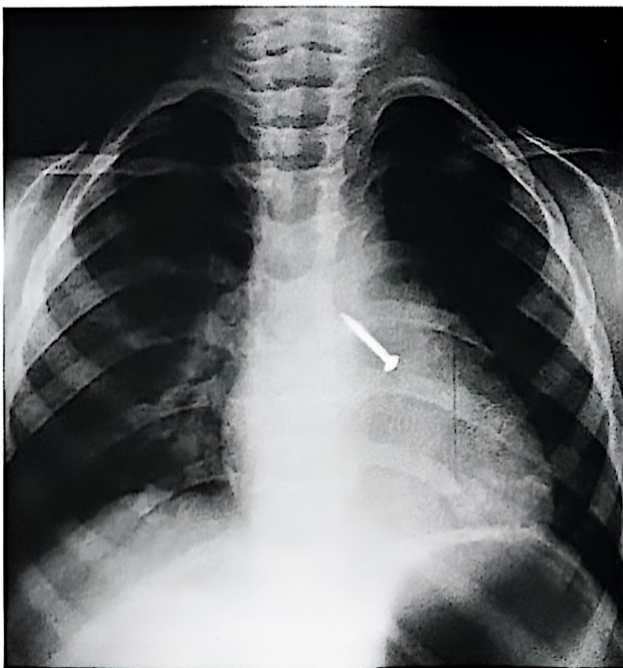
Posteroanterior chest radiograph shows foreign body (nail) aspirated into left main bronchus.
